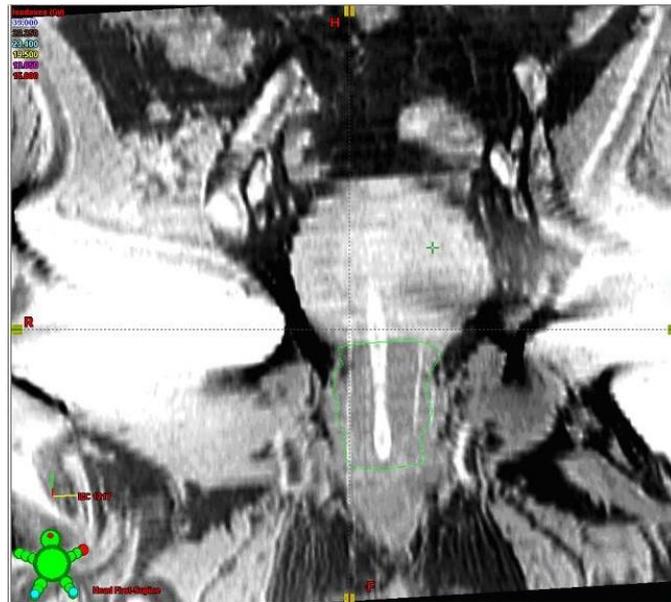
Coronal MR image from Patient #2. Image greyscale inverted and window adjusted to maximise visualisation of air-filled needles. T1 TSE, 1170 ms TR, 12 ms TE, COL phase encoding direction, 150° flip angle, 3 mm slice thickness.
